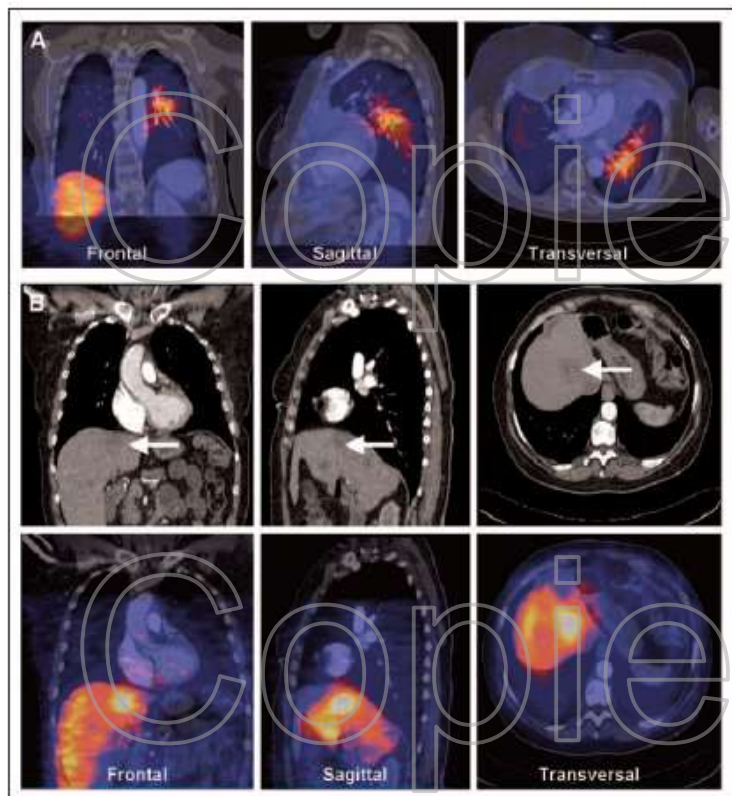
(A) Fused computed tomography (CT) with indium-111–diethylenetriamine penta-acetic acid anhydride ( $^{111}\text{In}$ -DTPA)-trastuzumab single-photon emission tomography (SPECT) image 196 hours after tracer injection. (B) CT images (top) of a patient with a large liver metastasis ( $\rightarrow$ ). Fusion with  $^{111}\text{In}$ -DTPA-trastuzumab SPECT (bottom) shows correspondence of liver metastases and SPECT hot spot.
